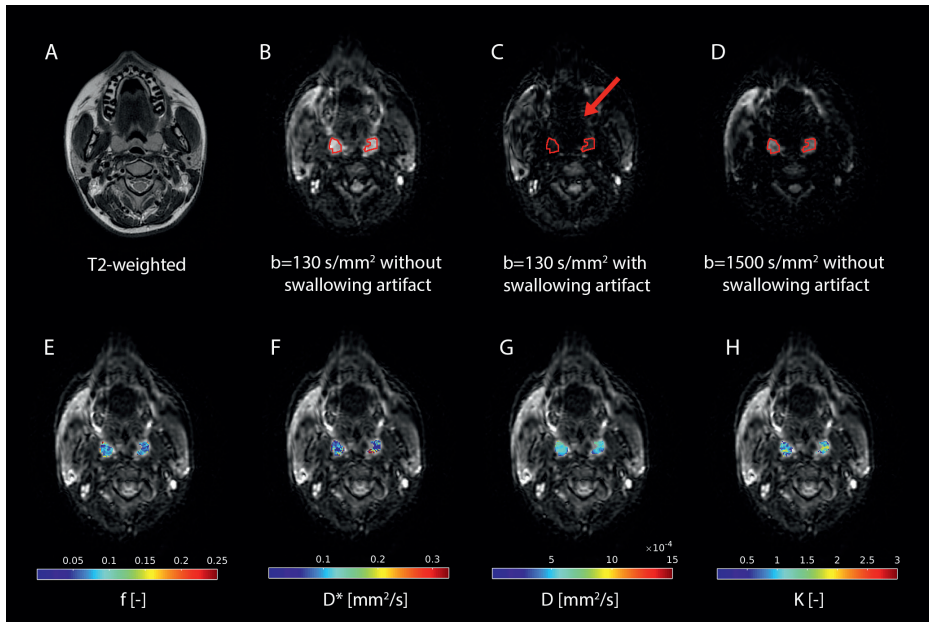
(A) Axial T2-weighted slice with (B) corresponding $b=130 \text{ s/mm}^2$ axial slice with the tonsils outlined in red and (C) identical slice to B but affected by a swallowing artifact. In (D) the same slice is shown but for $b=1500 \text{ s/mm}^2$. In the bottom row parametric maps for the tonsils are shown as color overlays on the corresponding $b=0 \text{ s/mm}^2$ slice with in (E) f , in (F) D^* in mm^2/s , in (G) D in mm^2/s , and in (H) K . D , diffusion coefficient, D^* , pseudo-diffusion coefficient; f , perfusion fraction; K , kurtosis.
